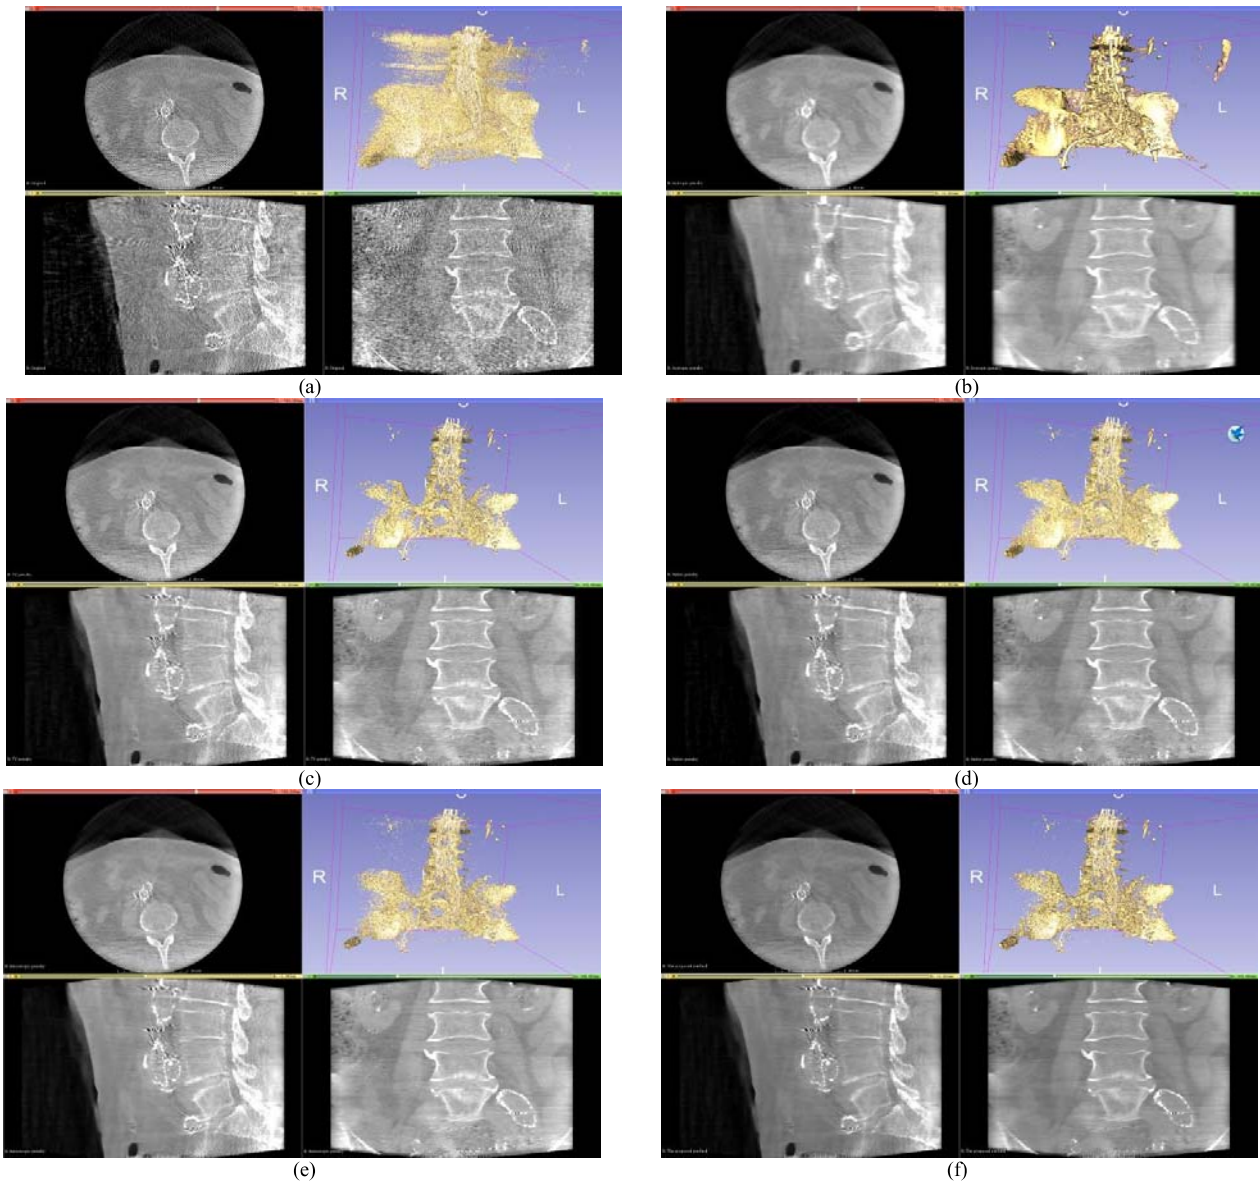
Post-deployment CBCT: (a) original CBCT, (b) result from the isotropic penalty, (c) result from the TV penalty, (d) result from the Huber penalty, (e) result from the anisotropic penalty, (f) result from the proposed edge-preserving penalty.
